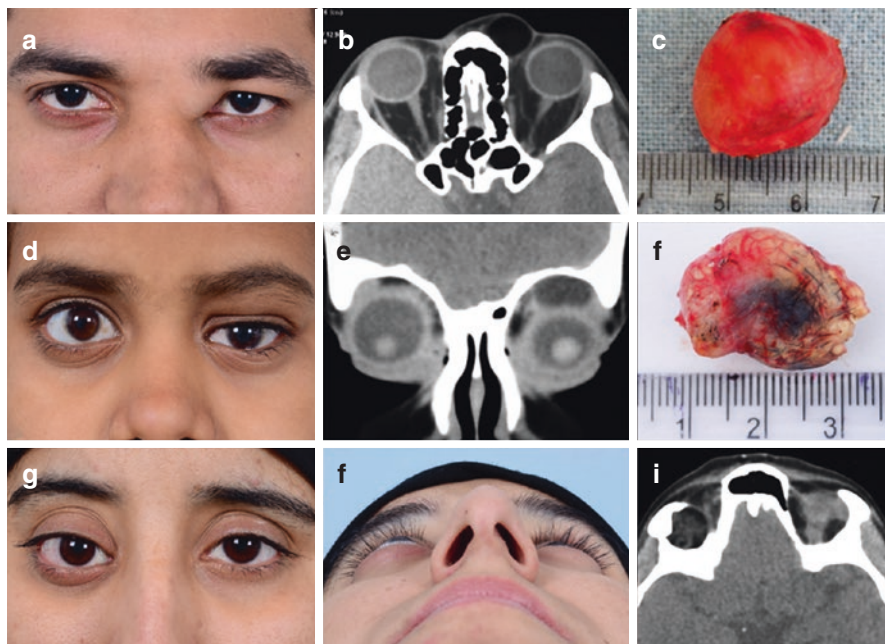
Orbital dermoid cyst. (a) A 28-year-old male with an internal angular dermoid left orbit. (b) Axial CT orbit showing a cystic lesion in the left superomedial orbit. (c) Gross appearance of the intact dermoid of the same patient showing a well-circumscribed encapsulated lesion. (d) A 10-year-old female with a large dermoid in the superior left orbit. (e) Coronal CT orbit demonstrates downward displacement of the left globe by the cystic lesion (hypoglobus). (f) Gross appearance of the large dermoid with presence of hair on the tumor surface. (g) A 19-year-old female with right hypoglobus. (h) Worm's eye view shows right proptosis. (i) Axial CT orbit reveals the presence of a large deep orbital cystic lesion
